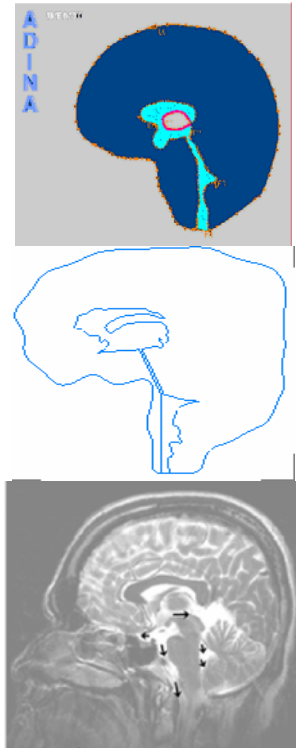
2D modeling from MRI image.
